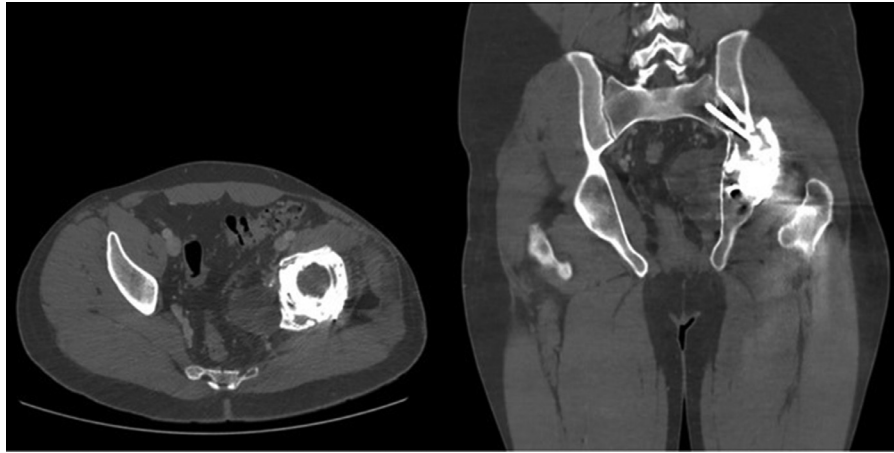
CT axial and coronal reconstruction demonstrates recurrence of echinococcus disease starting from the posterior acetabular wall and involving soft tissues medial to the coxo-femoral joint.
